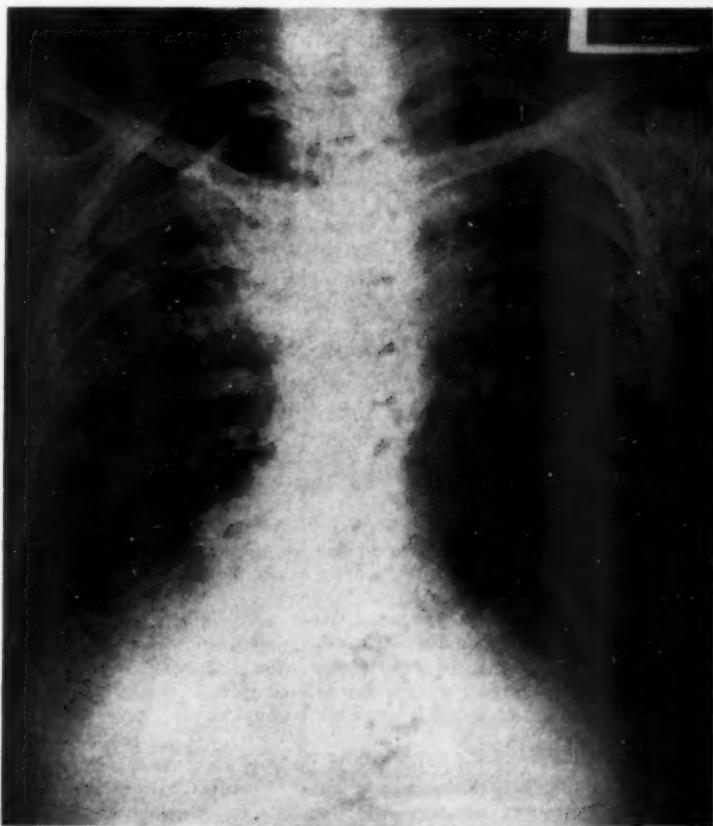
Radiograph taken in September, 1948, showing increased mediastinal shadow and apical pneumothorax.
